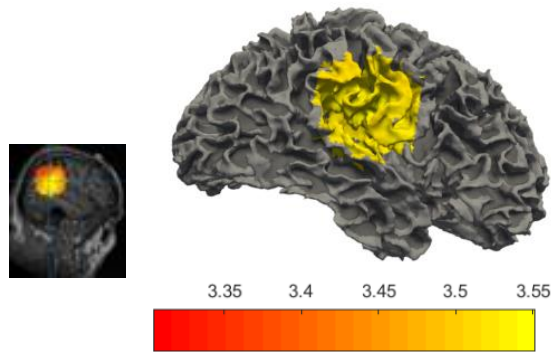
Source localisation for Patient P016 using Solution 1, 2, 3, 4 and validations. (a) Solution 1 and (b) Solution 3 co-localized to left posterior inferior temporal, while (b) Solution 2 and (d) Solution 4 localized to left inferior frontal gyrus. The kurtosis value of Solution 3 is 17.96. The subfigures of (a), (b), (c) and (d) show the corresponding sources registered onto the MRI images. In the colour maps shown in (a), (b) and (c), yellow represents the highest kurtosis value and red represents the lowest values. . (e) The validations used in this study, in which surgically resected areas are indicated by the blue surface and pink discs indicate the clinically localized results. In clinical EEG-MEG source localisation, the onset of the source located at rectal gyrus then propagate to medial orbitofrontal gyrus, later to lateral orbitofrontal gyrus. This propagation process is indicated by pink discs with white number 1, 2 and 3.
